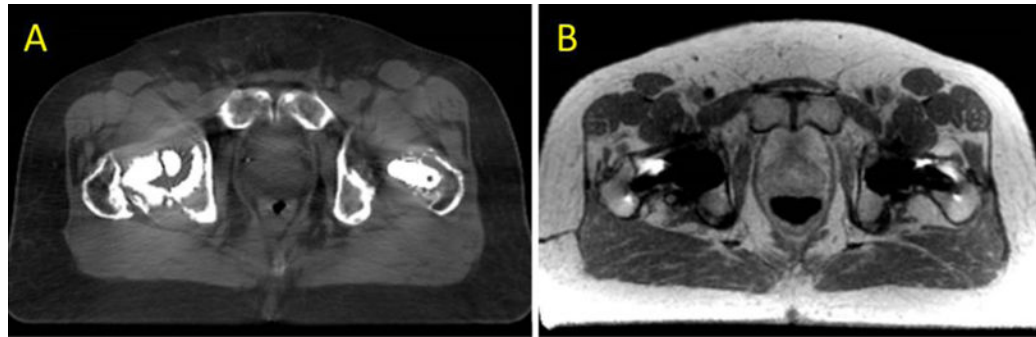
MAR for CT-SIM (A) and MR-SIM (B) in a prostate cancer patient with bilateral hip implants.
